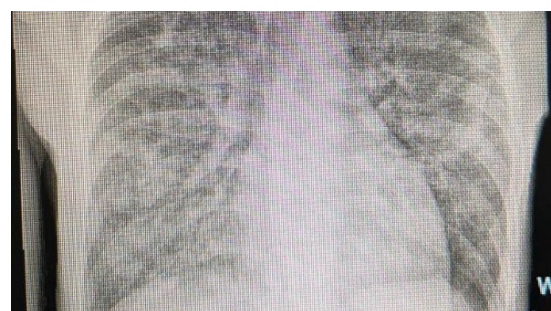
Chest X-ray of the patient at the time care was initiated.
